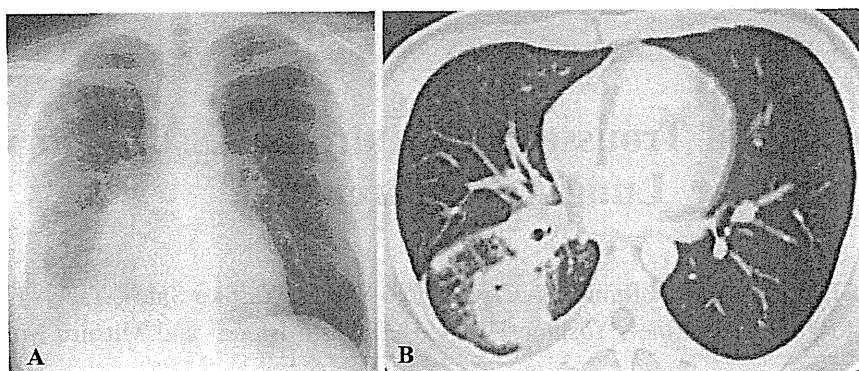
Chest X-ray of Case 1 showed radiolucent fall in the right lower lung field (A). CT demonstrated a mass 6 cm in diameter in the right lower lobe with right pleural effusion (B).
